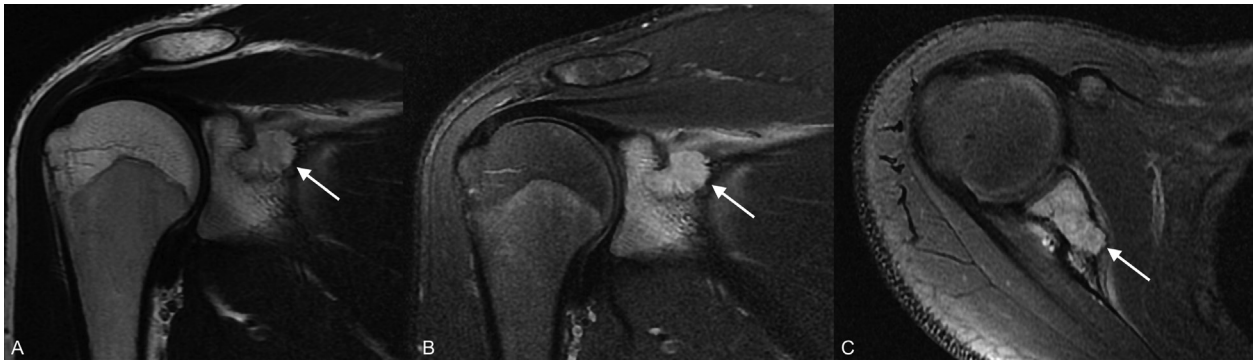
Coronal and axial view of MRI of the shoulder (A-C) expansile lesion that originates from the superior glenoid process, in the anterosuperior spine of the right scapula. the lesion shows high intensity on T2-weighted and low intensity on T1-weighted images. Important bone marrow edema is seen in the scapula, the lesion extends from the cortical bone to the adjacent soft tissues with compression of the suprascapular neurovascular bundle. The characteristic of the lesion and the extensive edema suggested a cartilaginous type lesion (chondroblastoma).
